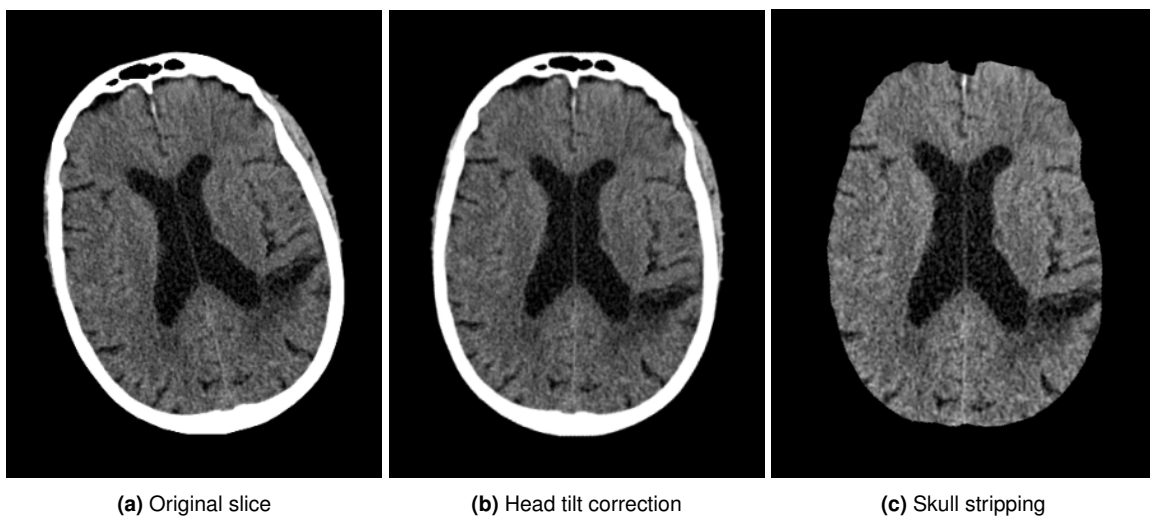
Main steps in CT images processing. Source: Images taken and adapted from HSM database.
